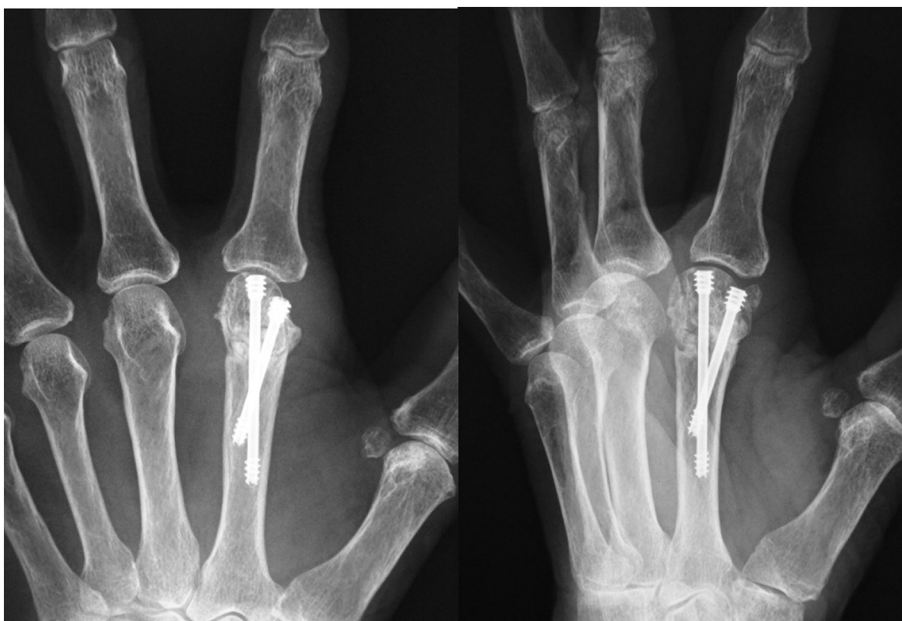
Radiography at 4 months postoperatively showing bone union without an indication of avascular necrosis.
